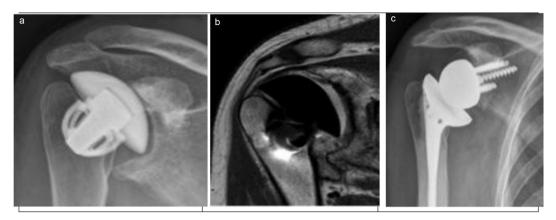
ab,c. X-ray (a), and MRI scan (b) revealing significant medialisation of a ceramic head Affinis hemiarthroplasty (Mathys, Switzerland) revised to (c) a Reverse Shoulder Arthroplasty (DJO Global, Austin, TX, USA) with iliac crest autograft whilst preserving the rotator cuff.
